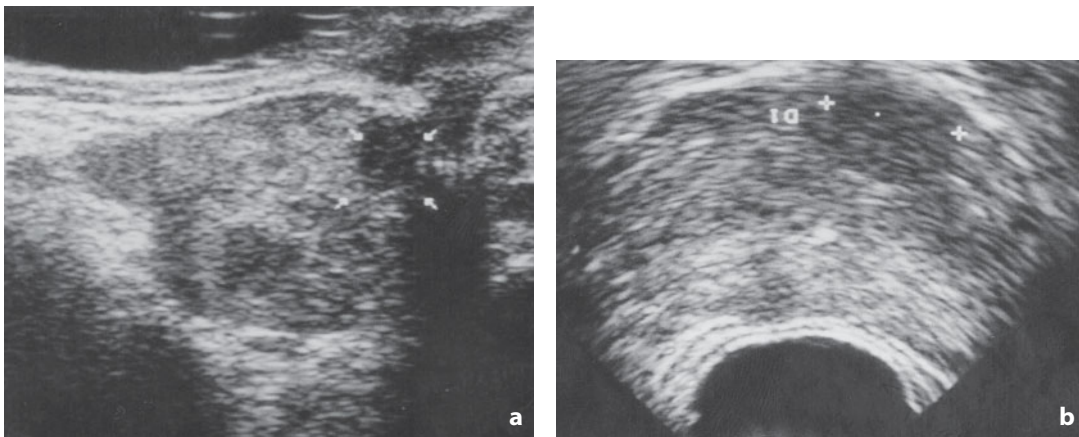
Ultrasonography. Transrectal approach. Prostatic adenocarcinoma. a Sagittal scan. A hypoechoic focal lesion with well-defined margins is apparent in the peripheral zone bounded by *small arrows*. b Axial scan. The nodule is identifiable by the greater hypoechoicity
